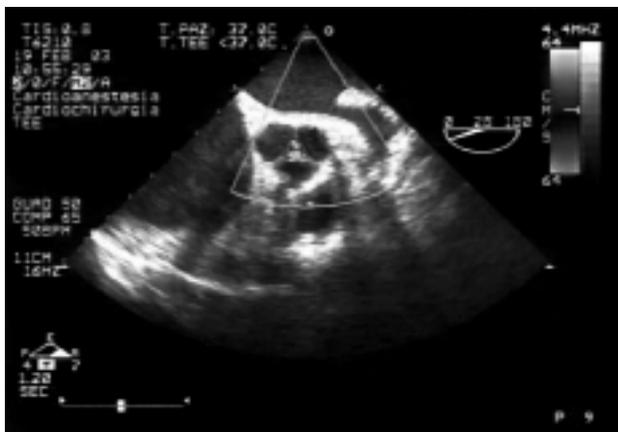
Transesophageal echocardiography: preoperative image of the aortic valve showing moderate central regurgitation.
